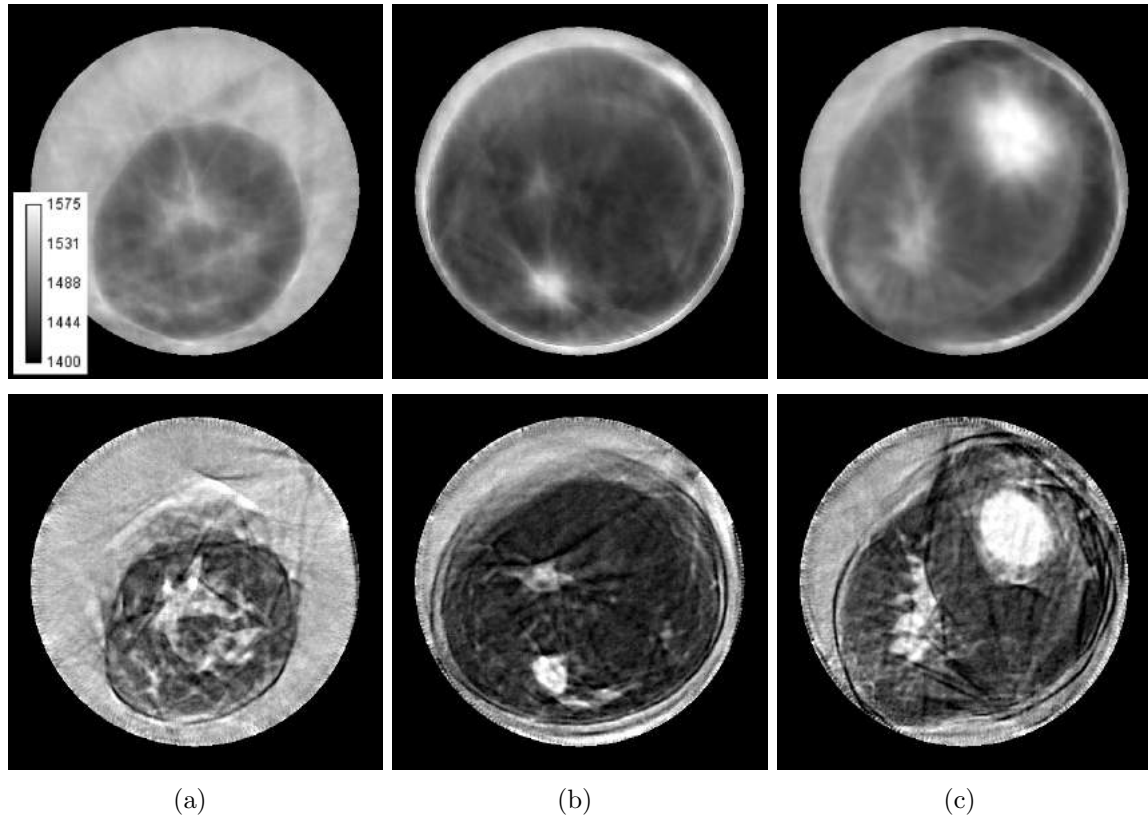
Comparison of Travel Time (top row) and Waveform (bottom row) Reconstruction Methods. Data acquired using older ultrasound tomography unit. Gray scale values in the sound speed images correspond to a range of 1400–1575 m/s. Brighter areas correspond to higher sound speed. (a) Complex parenchyma shape. (b) 1.5 cm tumor. (c) 4 cm tumor (1 o'clock) and parenchyma (9 o'clock).
